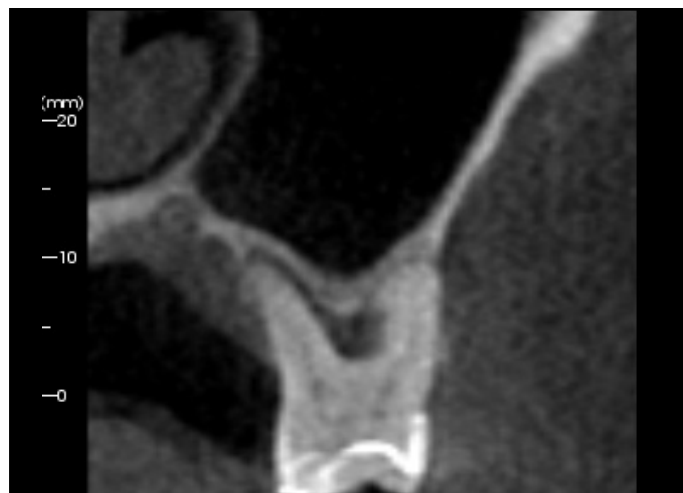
Presurgical CBCT scan of left maxillary sinus showing sinus pneumatization.
